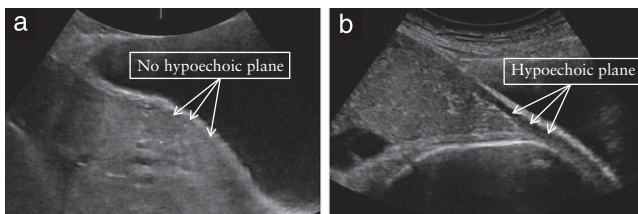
Loss of the 'clear zone' (a) and a normal example for comparison (b) on grayscale ultrasound.
